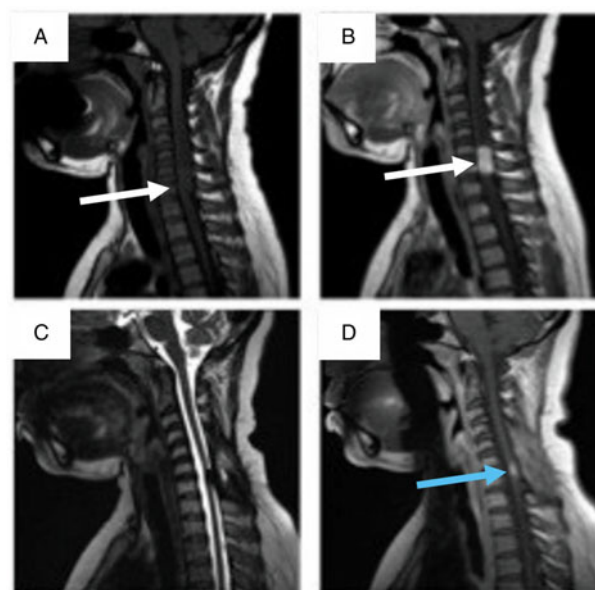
T1-weighted preoperative precontrast (A) and postcontrast (B) sagittal MRI demonstrates marked enhancement of this lesion at the level of C5-C7. Sagittal T2 (C) and T1 postcontrast (D) MRI images demonstrate minimal residual tumor 1 year postoperatively.
